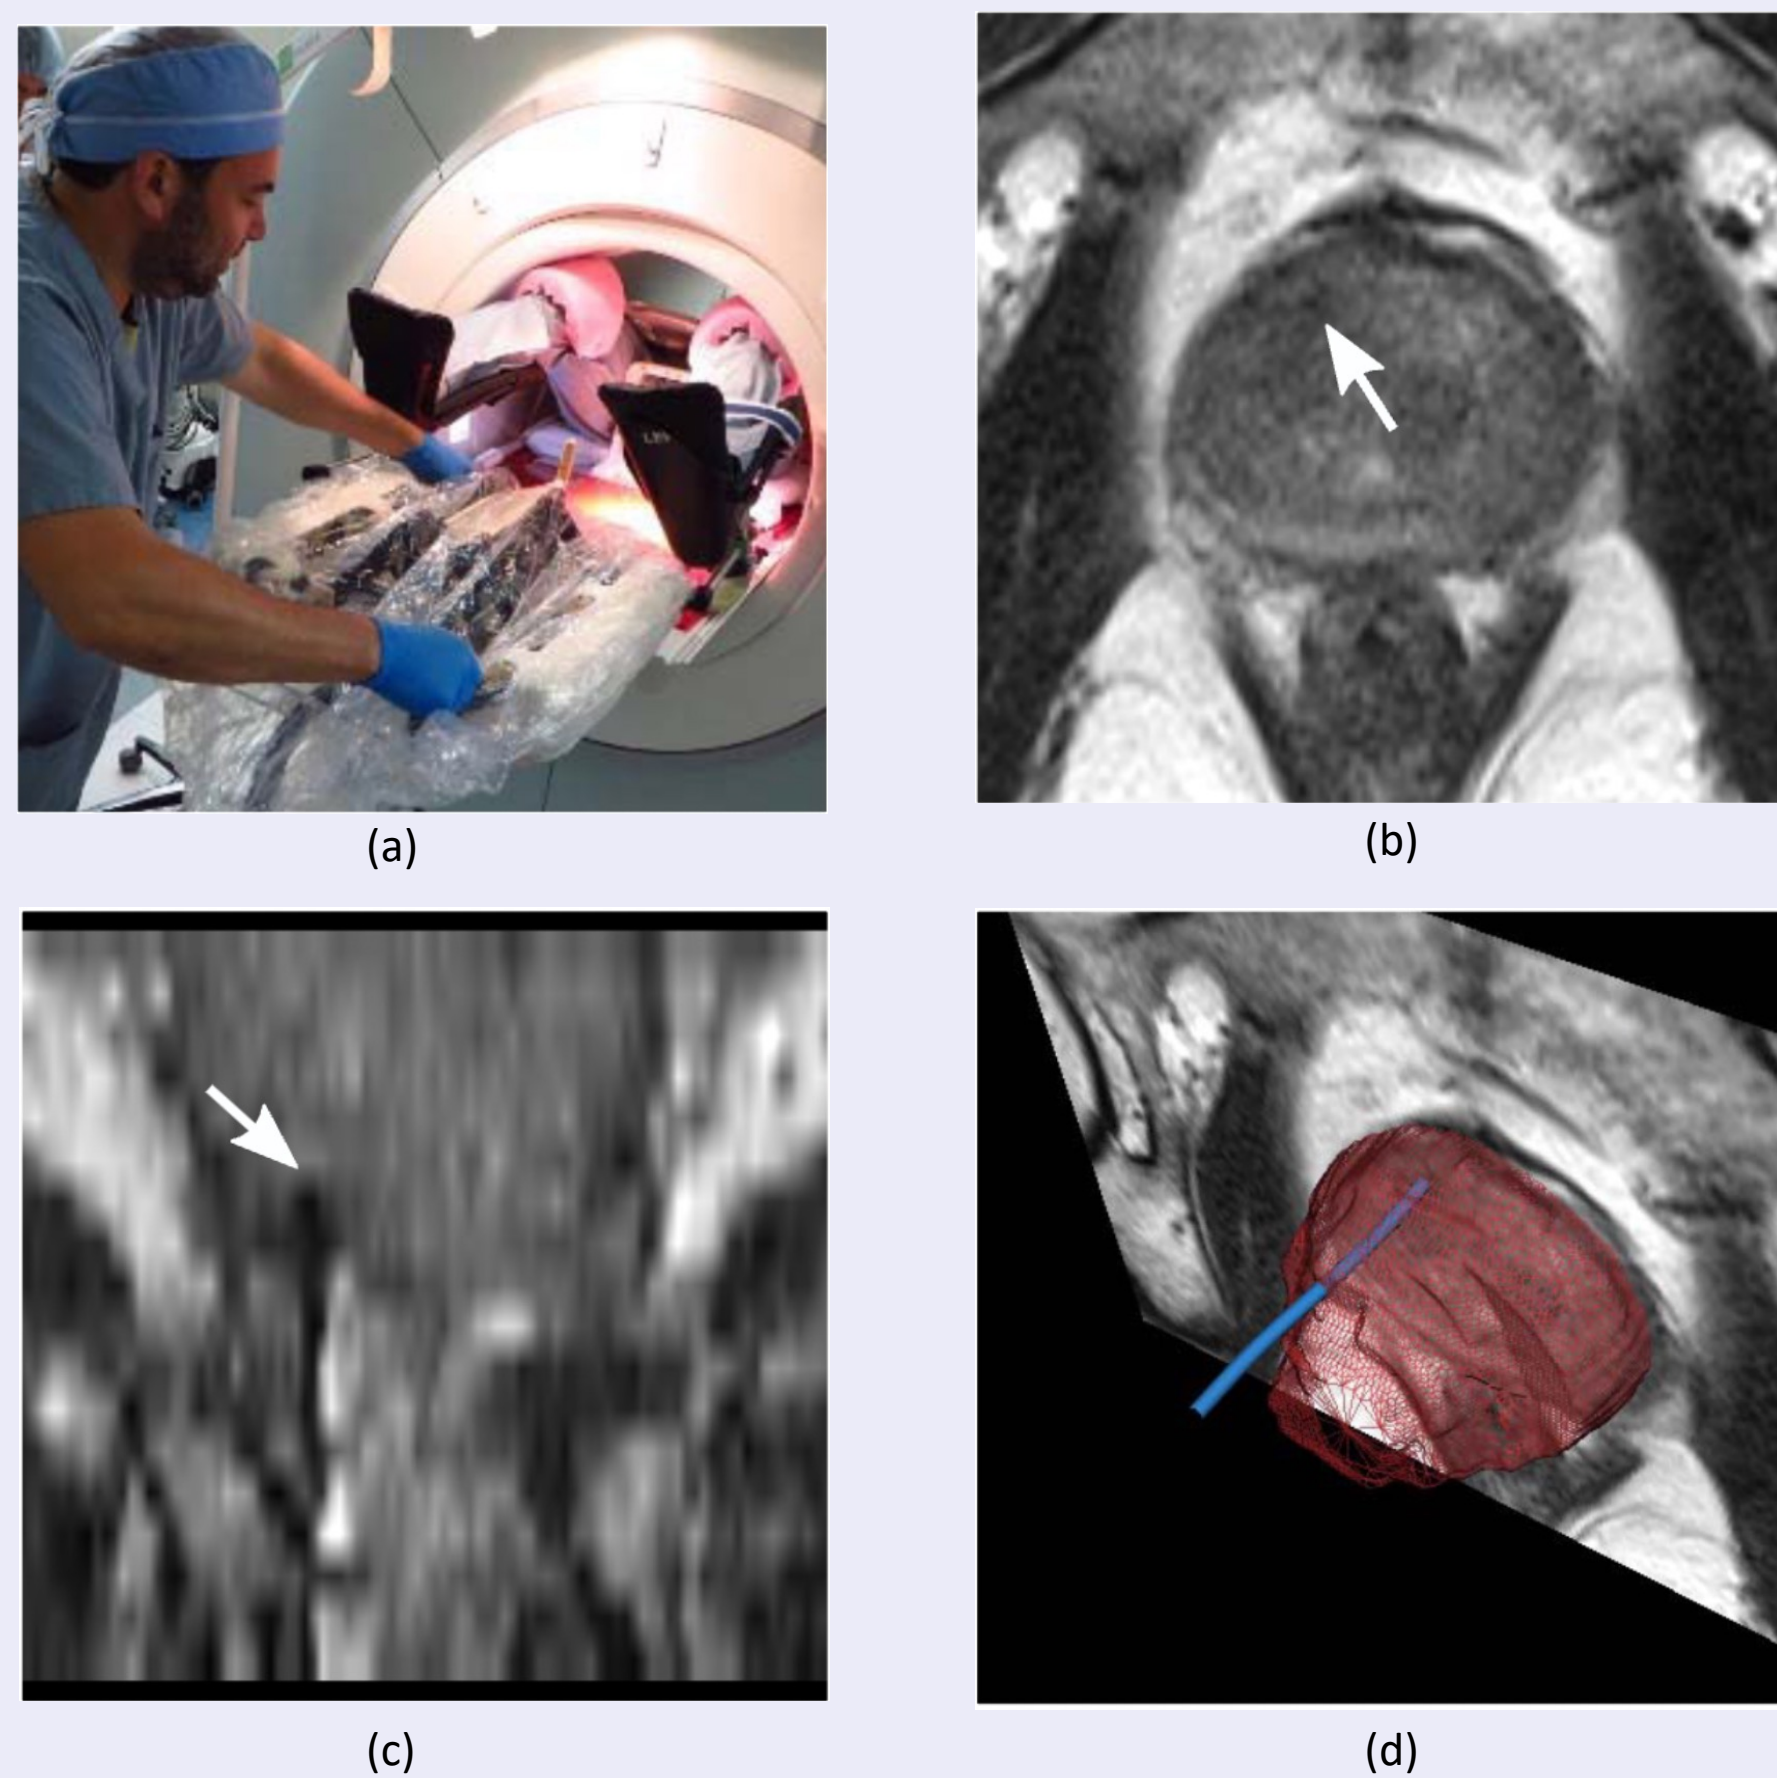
(a) The patient is placed in the supine position in the MRI gantry, and his legs are elevated to allow for transperineal access. The skin of the perineum is prepared and draped in a sterile manner, and the needle guidance template is positioned. (b) and (c) Axial and coronal views of intraprocedural T2-W MRI with needle tip marked by white arrow. (d) 3D rendering of the needle (blue), segmented by my method, and visualized relative to the liver, and an MRI cross-section that is orthogonal to the plane containing the needle tip.
